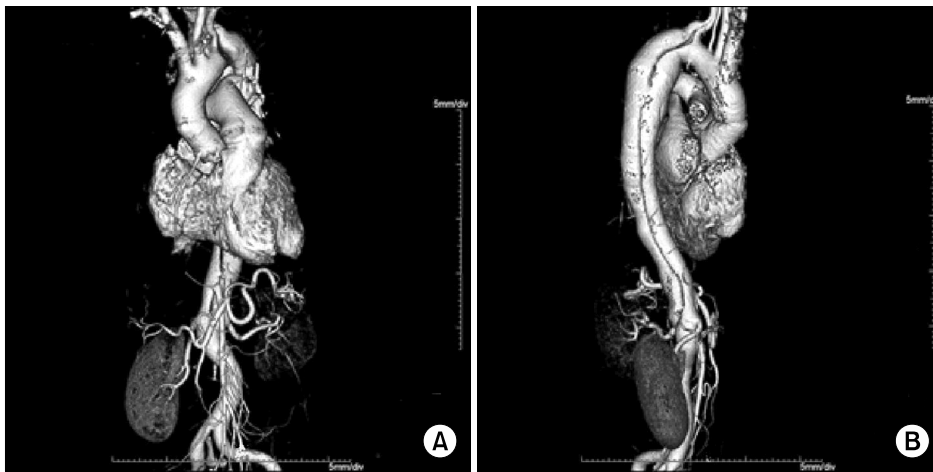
Follow-up 3-dimensional computed tomography angiogram. (A) Normal ascending aorta (after the Bentall operation). (B) No interval change of the descending aortic dissection.
